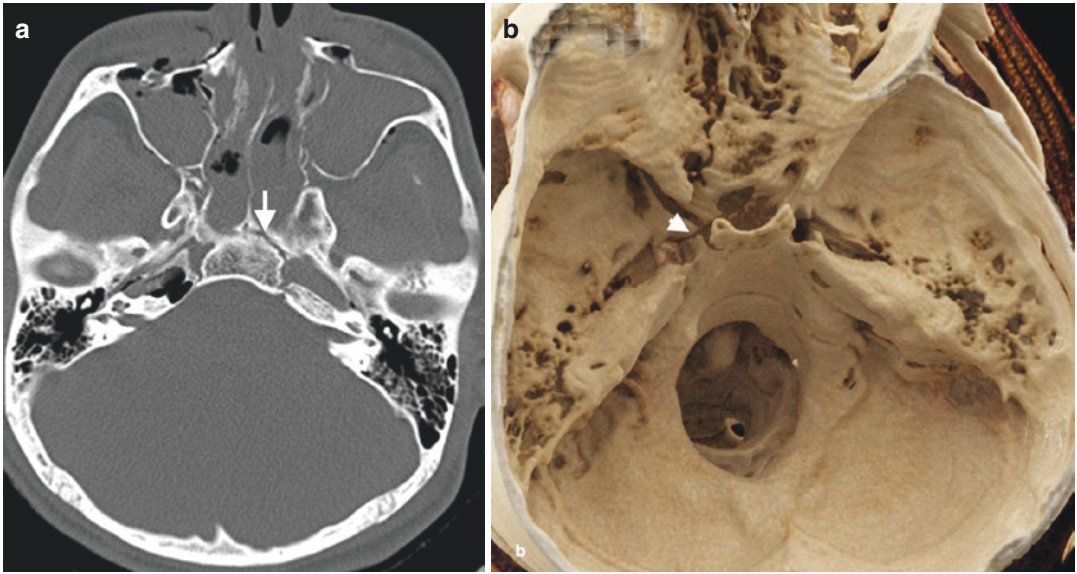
MSB fracture involving left lateral wall of the sphenoid sinus. (a) Axial CT image reveals an obliquely oriented fracture (arrow) through left anterolateral wall of the sella. (b) CR image demonstrates fracture (arrowhead) of the left lateral wall of the sphenoid sinus
